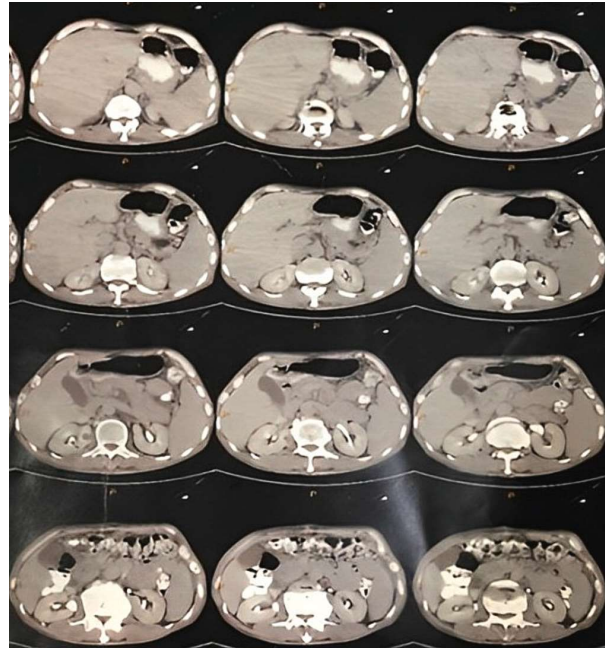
Abdominal computed tomography scan showed multiple intra-abdominal tumors in patient with biopsy-proven actinomycosis.
